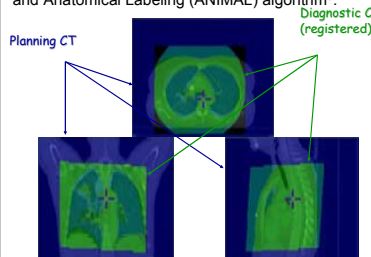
Diagnostic CT registered to planning CT.
